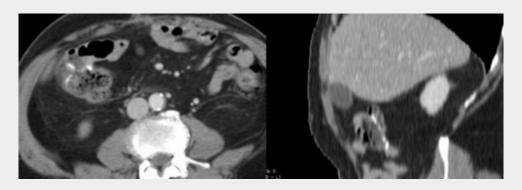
Abdominal CT of a patient who underwent left colectomy
